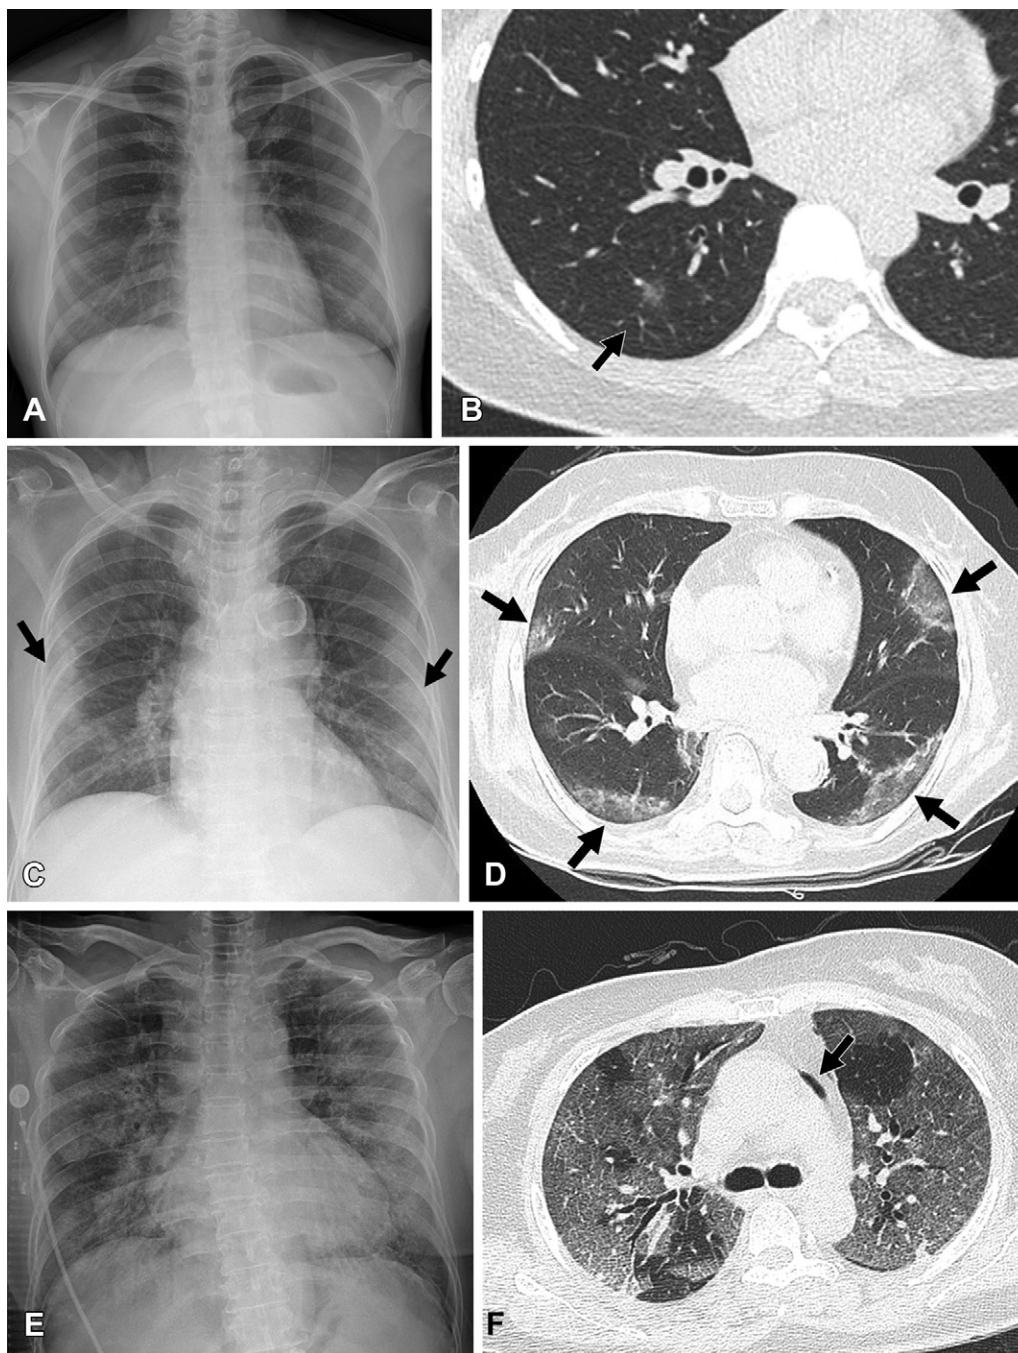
Chest radiographic and CT findings of COVID-19 pneumonia according to disease stage and lesion extent. (A, B) COVID-19 pneumonia at the time of “early infection phase” in a 42-year-old woman who received a booster dose during Omicron variant–dominant period. (A) Chest radiograph obtained 3 days after the positive nucleic acid amplification test shows no abnormal opacification in either lung. (B) Transverse nonenhanced CT scan (lung window) obtained at level of basal trunk and on the same day shows an ill-defined ground-glass opacity (GGO) nodule (arrow) in the superior segment of the right lower lobe. (C, D) COVID-19 pneumonia at the time of “pulmonary phase” in an 80-year-old fully vaccinated woman during Delta variant–dominant period. (C) Chest radiograph obtained 5 days after positive nucleic acid amplification test shows multifocal patchy consolidation and GGO (arrows) in both lungs with a peripheral predominance. (D) Transverse nonenhanced CT scan (lung window) obtained at the level of the inferior pulmonary vein and on the same day demonstrates patchy areas of mixed GGO and consolidation with subpleural distribution (arrows). (E, F) COVID-19 pneumonia at the time of “hyperinflammatory phase” in a 69-year-old unvaccinated woman with no underlying disease during Delta variant–dominant period. (E) Chest radiograph obtained 2 weeks after positive nucleic acid amplification test shows diffuse and extensive parenchymal opacity involving bilateral lungs. (F) Transverse nonenhanced CT scan (lung window) obtained at the level of carina and on the same day demonstrates diffuse and extensive areas of GGO with visible intralobular lines involving bilateral lungs. Also note pneumomediastinum at left paraaortic area (arrow). Even though the patient was treated with mechanical ventilation and extracorporeal membrane oxygenation, she succumbed to the disease.
